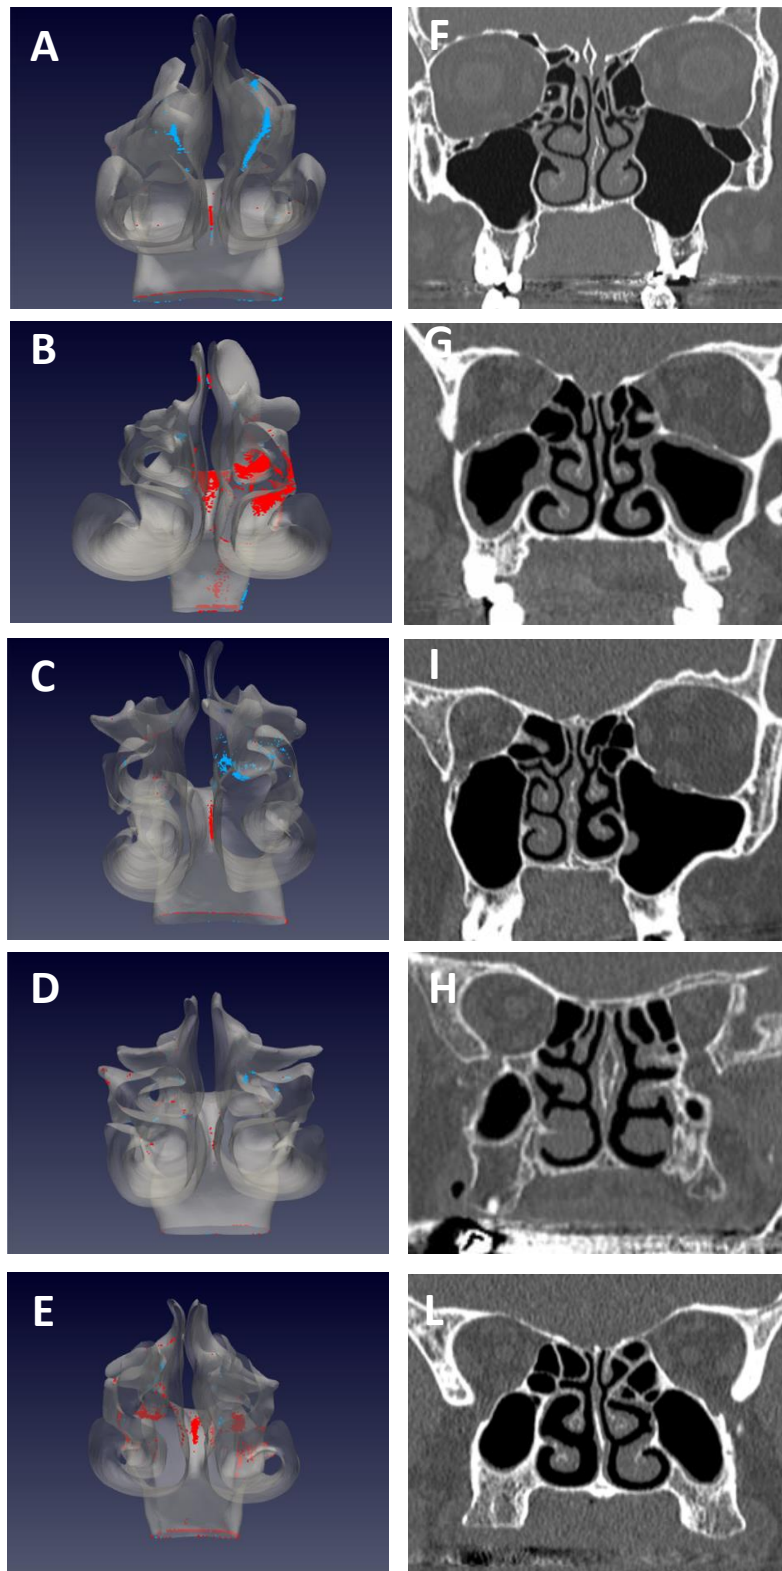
Probabilistic distribution of droplets from 5μ in inhalation (blue) and expiration (red), coronal projection. The A-E subunits show 3D models of both nasal cavities, obtained from the original CT scans of four patients, reported in the F-L subunits. Each 3D model is related to the corresponding TC image. The droplets size has been increased to improve clarity.
